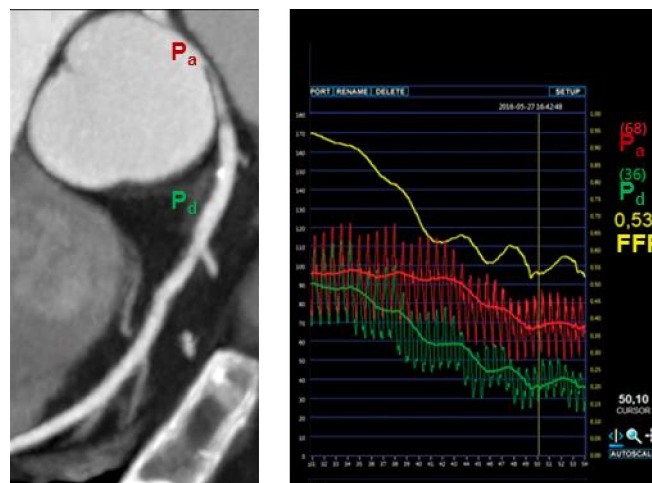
Use of FFR in clinical practice. Left: CT coronary angiogram of an AAOCA patient with proximally narrowed anomalous RCA. Right: proximal pressure waveform (red), distal pressure waveform (green) and FFR (yellow). Numbers are mean values of the waveforms.
